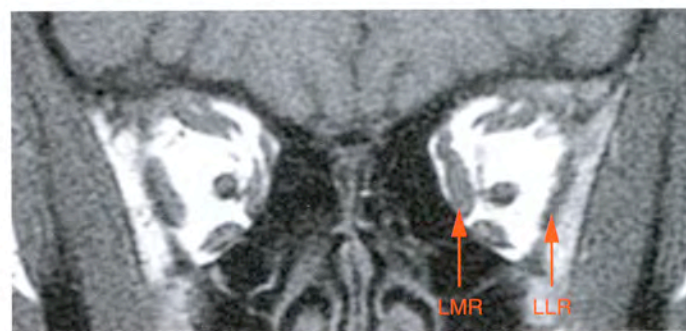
MRI of patient from Figure 87.3 at 224 days after second injection of left medial rectus (LMR) with BUP and left lateral rectus (LLR) with Botox®. Notice that the LMR is larger, and LLR is smaller than the corresponding muscles in the right eye.
